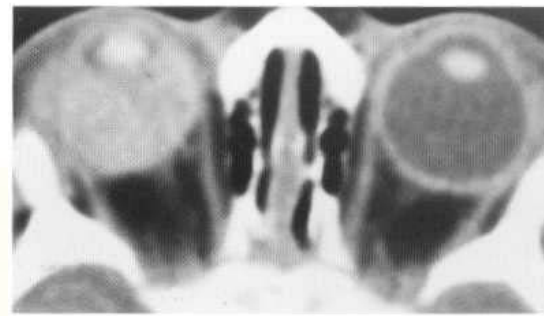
Persistent hyperplastic primary vitreous. Non-contrast axial CT demonstrates hyperdensity throughout the posterior compartment of the right eye.
